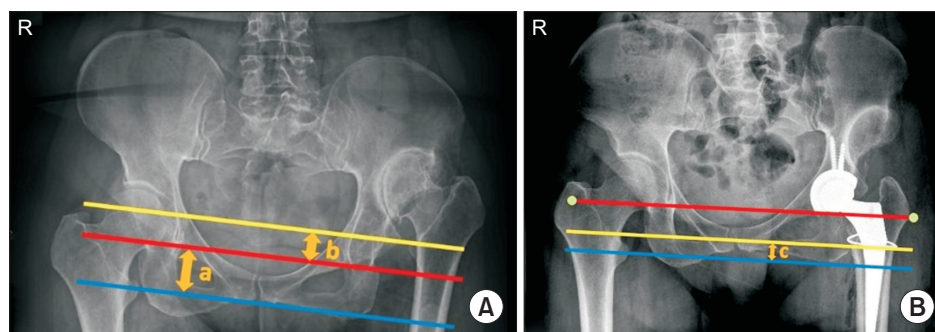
Measurement of hip dislocation height in preoperative (A) and postoperative (B) pelvis anteroposterior radiographs. Red line: inferior teardrop vertical line, Yellow line: the vertical line drawn from the tip of the lesser trochanter of the operated hip, Blue line: the vertical line drawn from the tip of the lesser trochanter of the unoperated hip. The distance between the yellow and blue lines represented the dislocation height. Thus, the sum of "a" and "b" is equal to the preoperative dislocation height of the left hip, and "c" is the postoperative difference in the hip heights.
